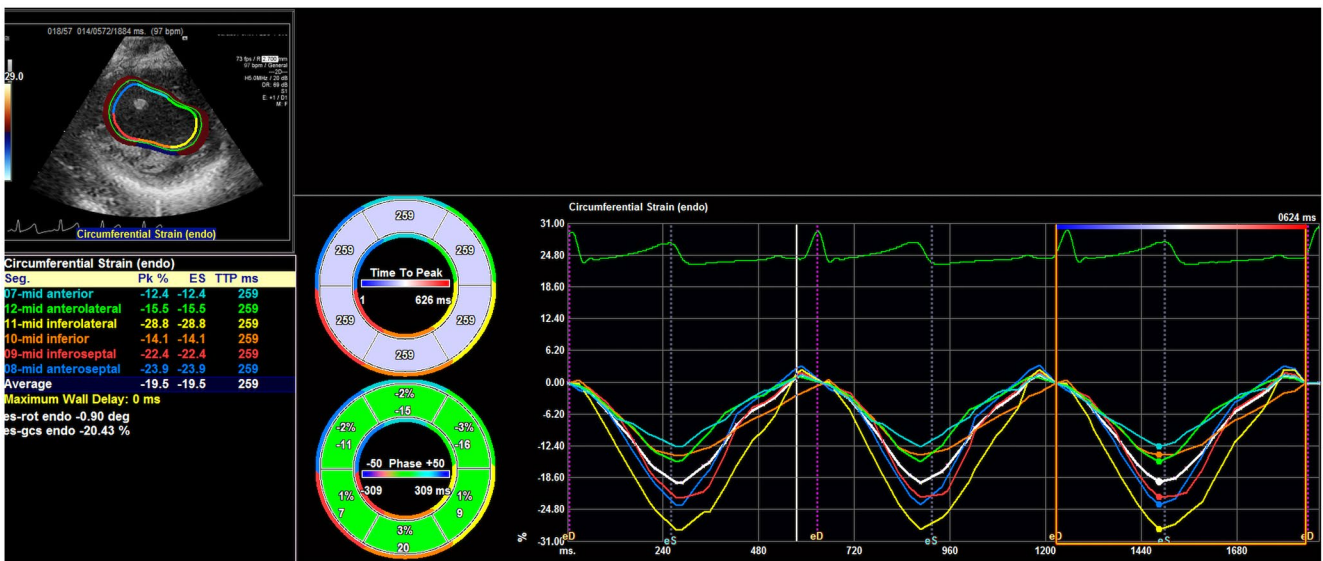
Example of a circumferential deformation echocardiogram tracing. Strain obtained in each segment (color coded) and also averaged into a global strain, seen in the bottom left. Waveforms of the strain during cardiac cycle is also included in the bottom left
